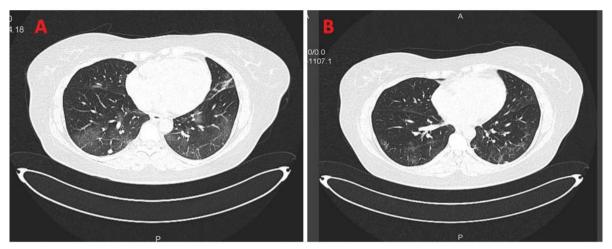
Thoracic computed tomography in a female patient with a moderate form of COVID-19. Bilateral infiltrates predominant at the level of the posterior and inferior pulmonary lobes, with a typical ground-glass aspect. Panel A. Acute phase of the disease; Panel B. Follow up at one month.
